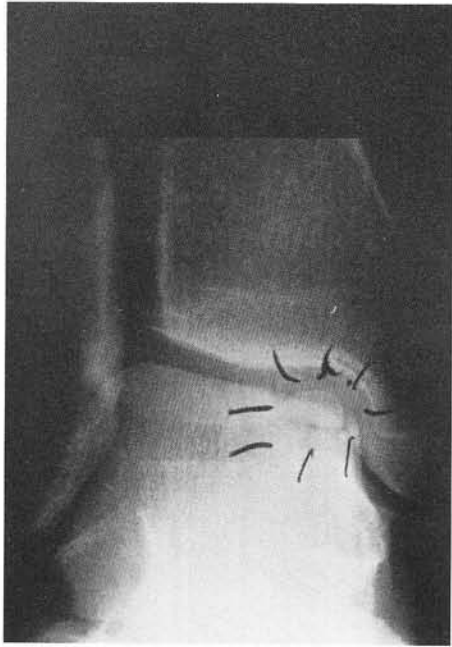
Preoperative AP radiograph
